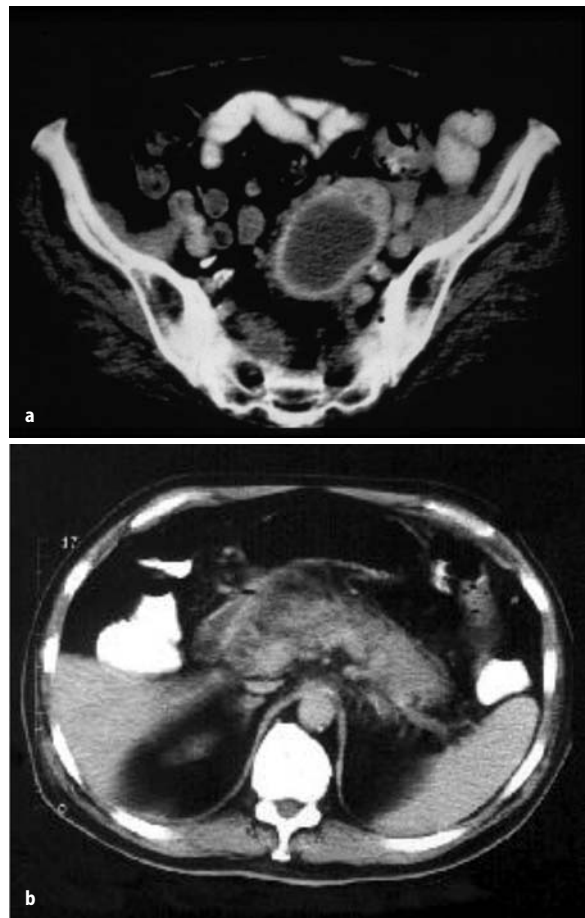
a Abscess from perforated colonic diverticulum identified by CT scan with double contrast. (Note enhancement of abscess rim, caused by hypervascularity and the interface of bacterial growth and the host.) b CT scan with double contrast demonstrating necrotizing pancreatitis with evidence of abscess formation by virtue of air bubbles in edematous peripancreatic tissue (*arrow*)
